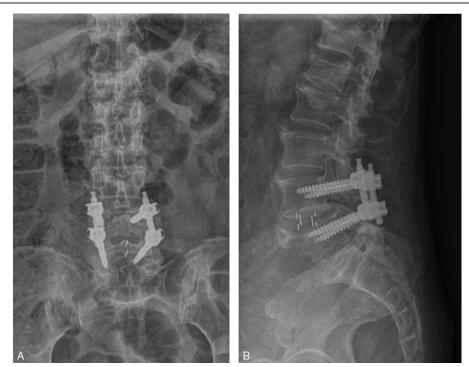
Postoperative plain anteroposterior (A), lateral (B) radiograph view of the lumbar spine showing L4-5 fusion.
